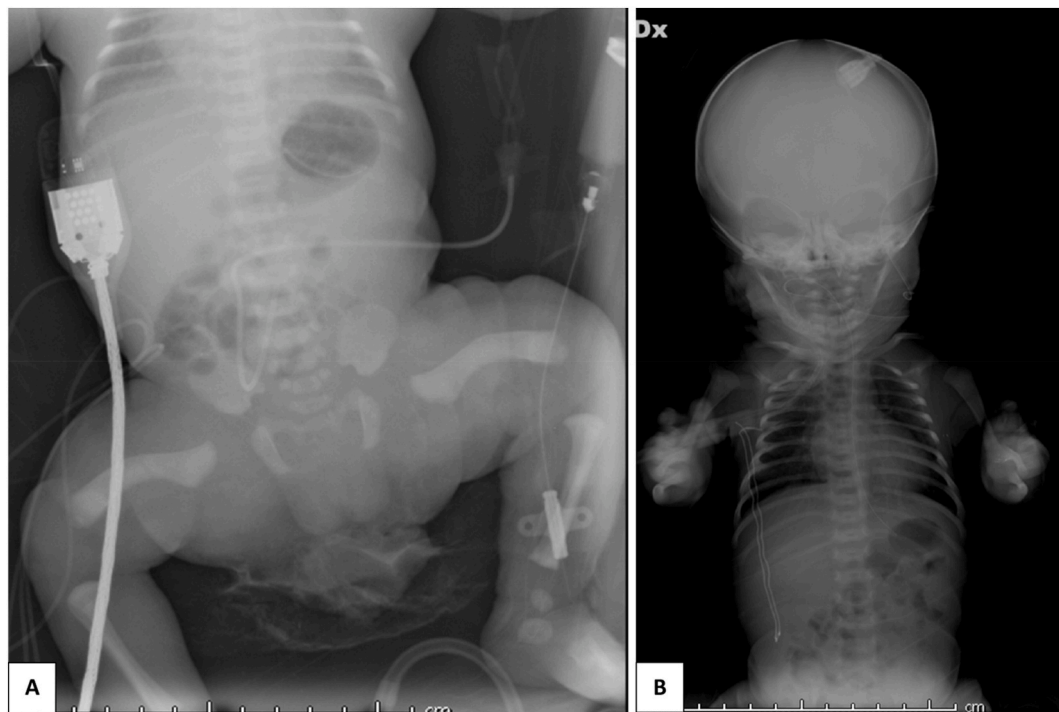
A: at birth skeleton X-ray shows shortened long bones and dumbbell-shaped femurs. 2B: Bell shaped thorax, with no spine nor skull anomalies.
